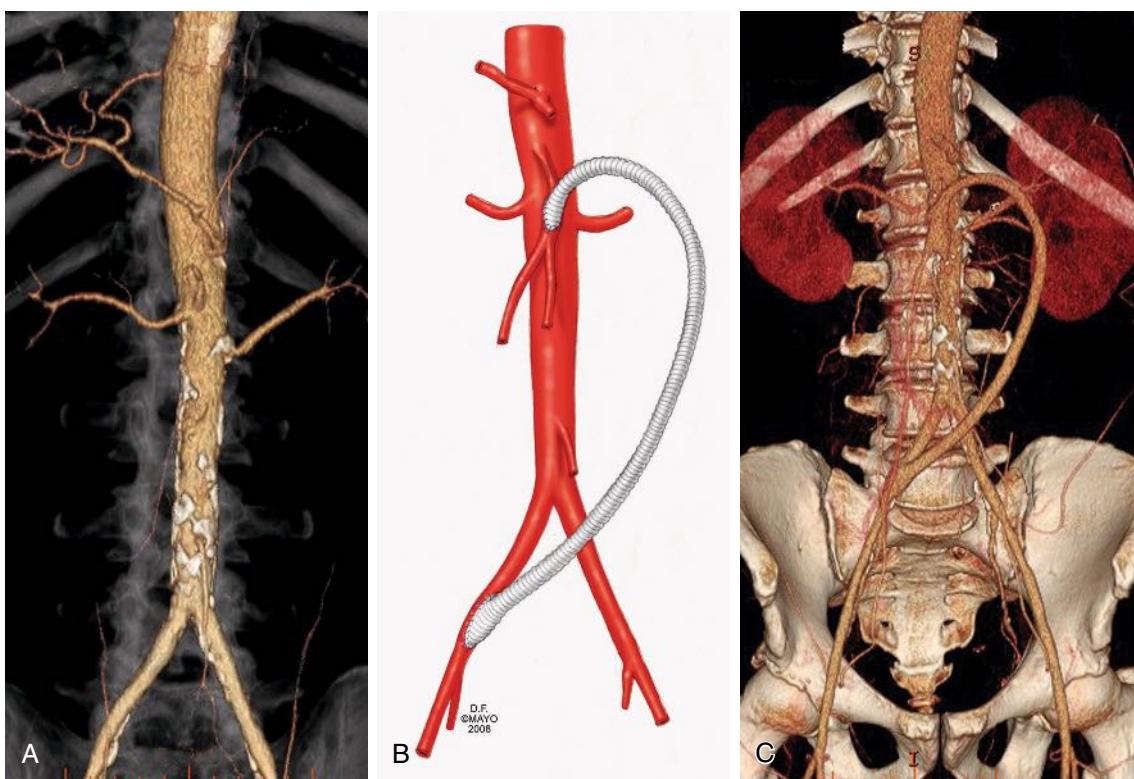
Computed tomography angiography (CTA) of a patient with vasculitis and occlusion of the superior mesenteric artery (A). The patient was treated by retrograde C-shaped iliac artery to superior mesenteric artery bypass (B). Follow-up CTA revealed widely patent bypass graft (C).
